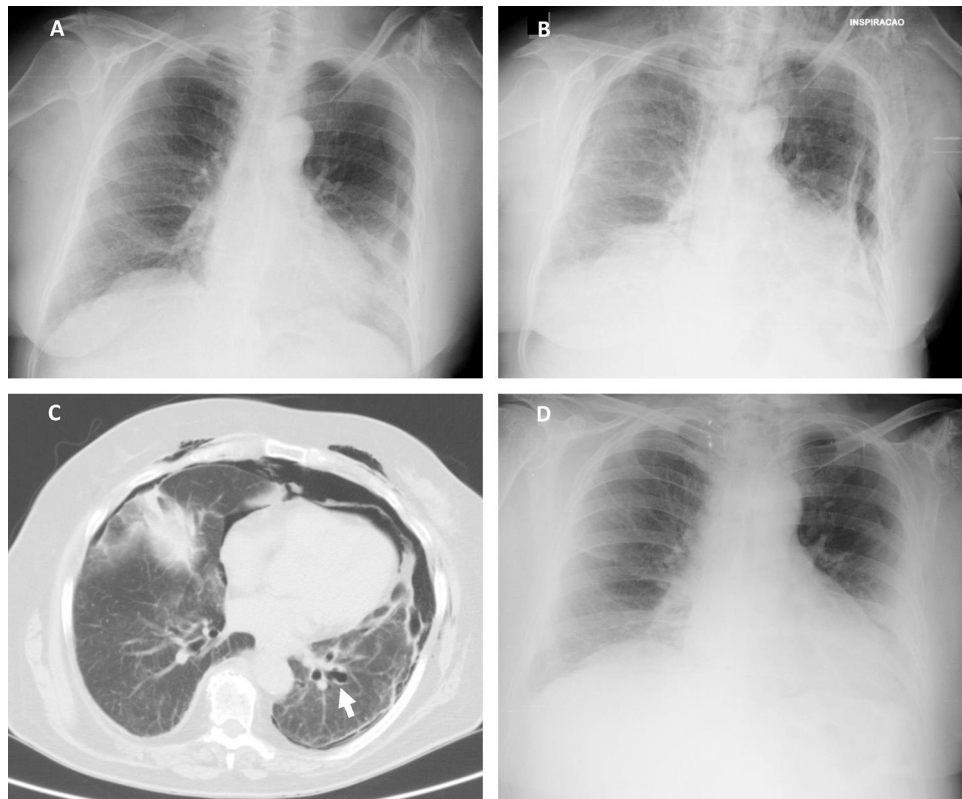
(A) Chest radiography 2 h following the cryobiopsy showing a marginal left pneumothorax. (B) Chest radiography 4 h after the procedure revealing bilateral pneumothorax, pneumomediastinum and subcutaneous emphysema. (C) Computed tomography scan revealing an enlarged area along the lateral basal segmental bronchus (arrow) suspicious of a bronchial laceration. (D) Chest radiography five days after the cryobiopsy showing resolution of the complications.
